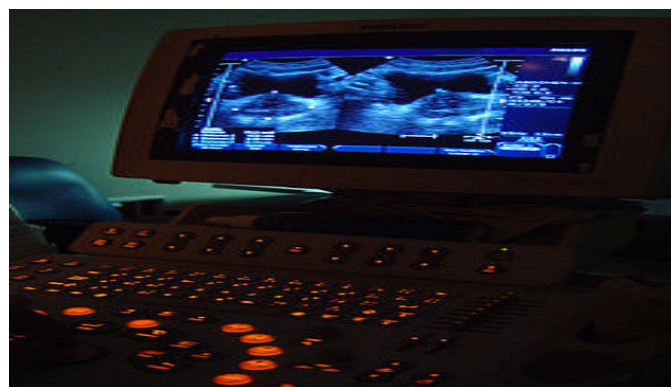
Medical ultrasonography technique
